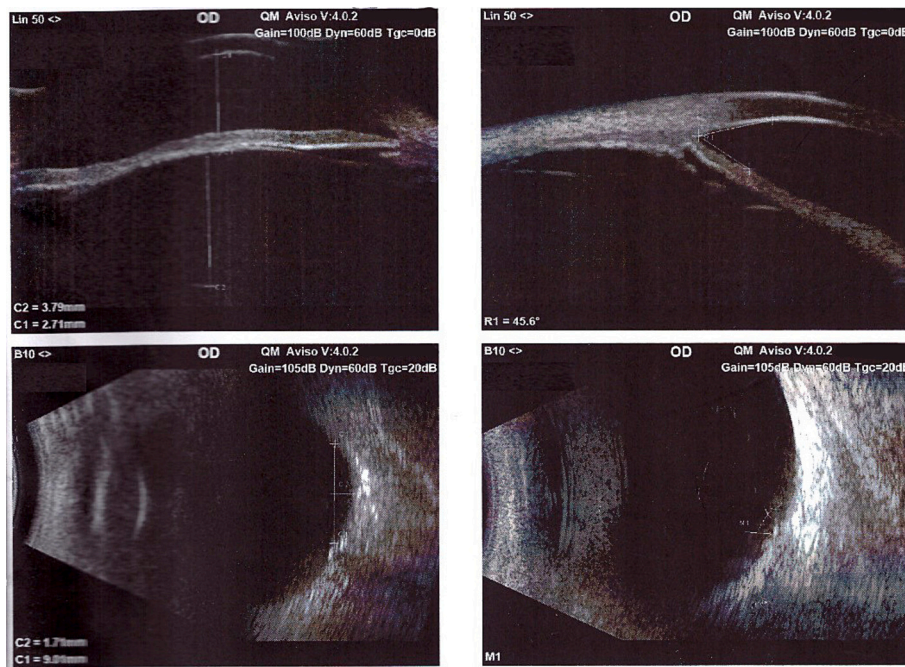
Ultrasound scanning of the right eye showing the anterior chamber of medium depth with the anterior chamber angle of about 45°. The total pupil aperture is absent. Single dot-fiber patterns of low echogenicity are detected in the lens. The retina is attached. Outside the optic disc, posterior staphyloma with a depth of 1.7 mm and a length of 9.0 is observed.
